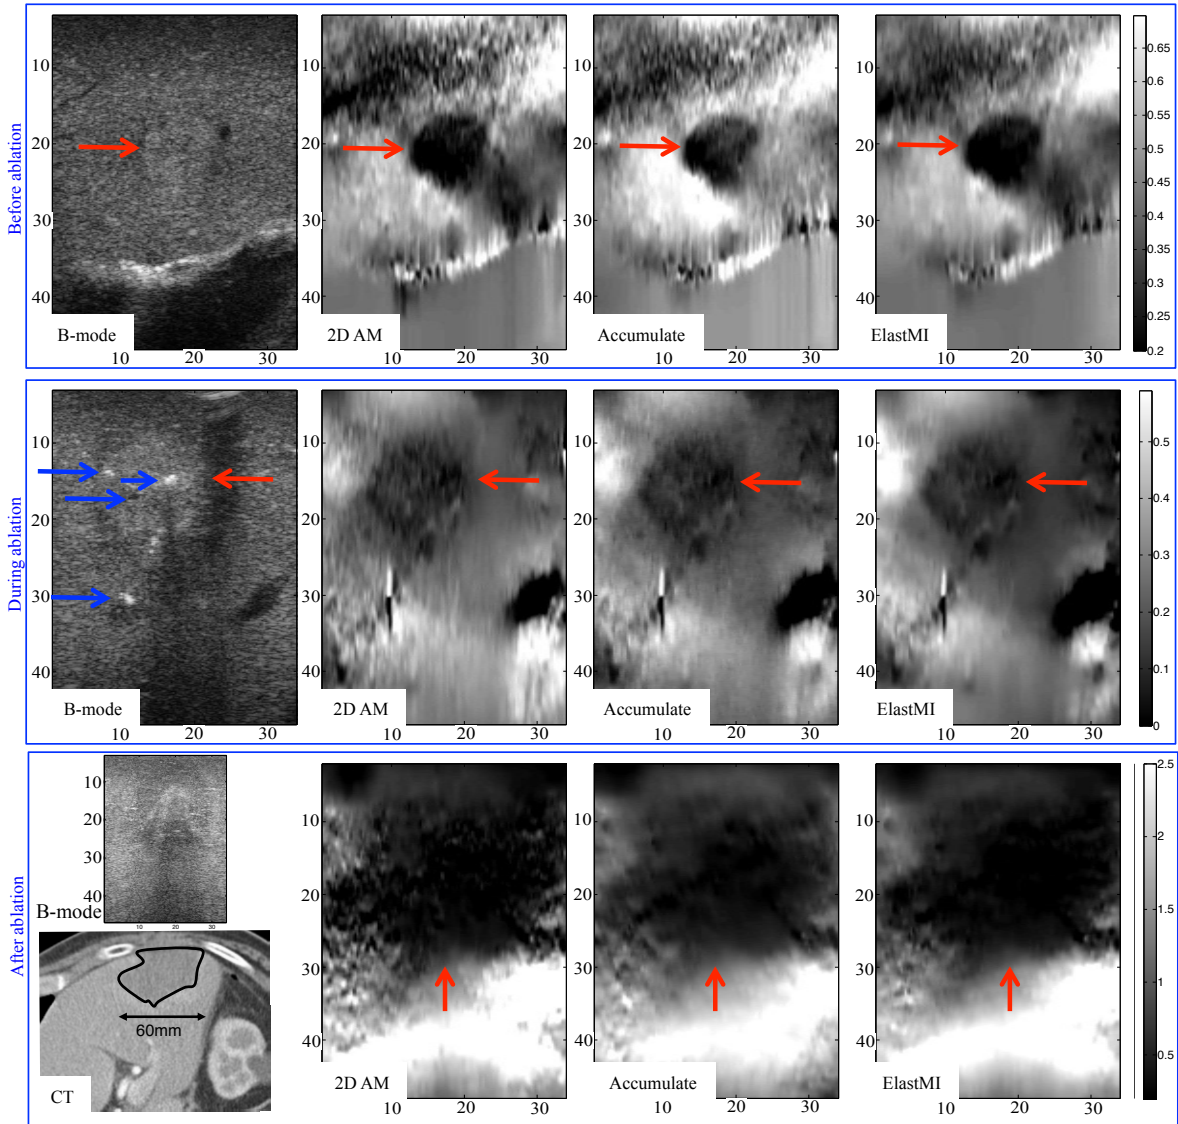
Strain images of the 3rd *in-vivo* patient trial corresponding to before (1st row), during (2nd row) and after (3rd row) ablation. All axes are in mm. The tumor in the top row, and the ablation lesion in second and third row are pointed to by arrows. Four prongs of the ablation probe are visible in the US image of the second row and are pointed to by arrows. CT is acquired 3 weeks after ablation. All axes in mm. See also Table 2.
